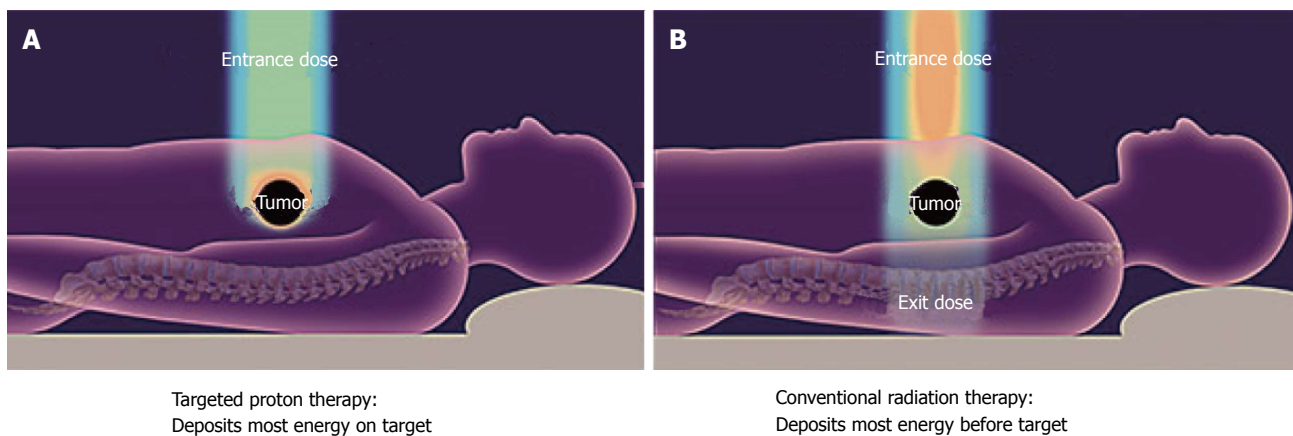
Conventional radiotherapy. With conventional radiotherapy (A) using X-rays (photons), the highest dose is deposited where the beam enters the patient. The dose at the tumor target is significantly less than the entry dose. Also, an exit dose is delivered beyond the tumor target. With protons (B), the entry dose is low. The highest dose is deposited at the depth of the tumor target, and there is no exit dose beyond the target.
